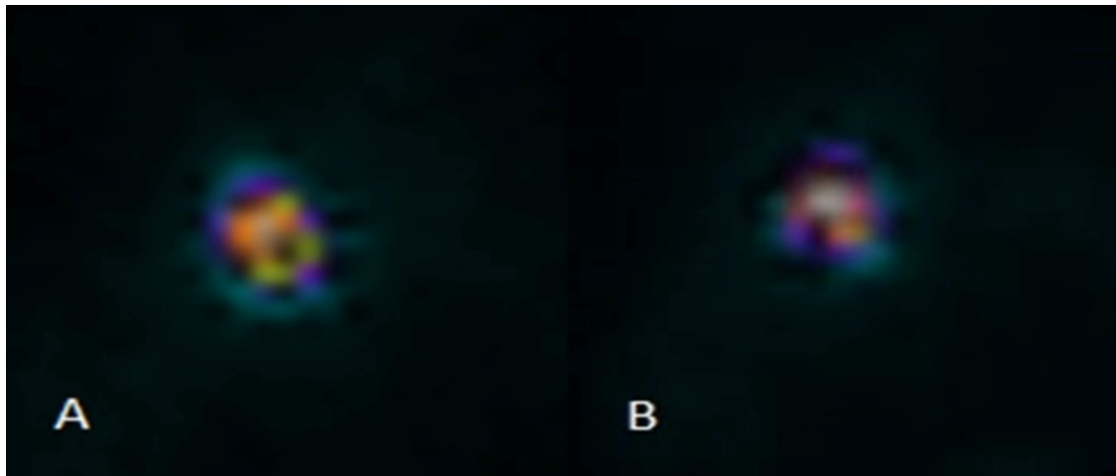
^{99m}Tc[Tc]-MIBI SPECT images of the breast cancer lesion in a patient. (A) Fifteen minutes after radiopharmaceutical injection, (B) 60 minutes after radiopharmaceutical injection
